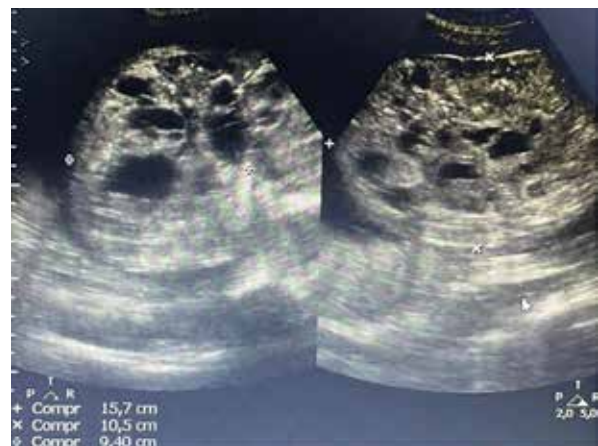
Ultrasound image of complex image, contiguous to the skull and fetal face
